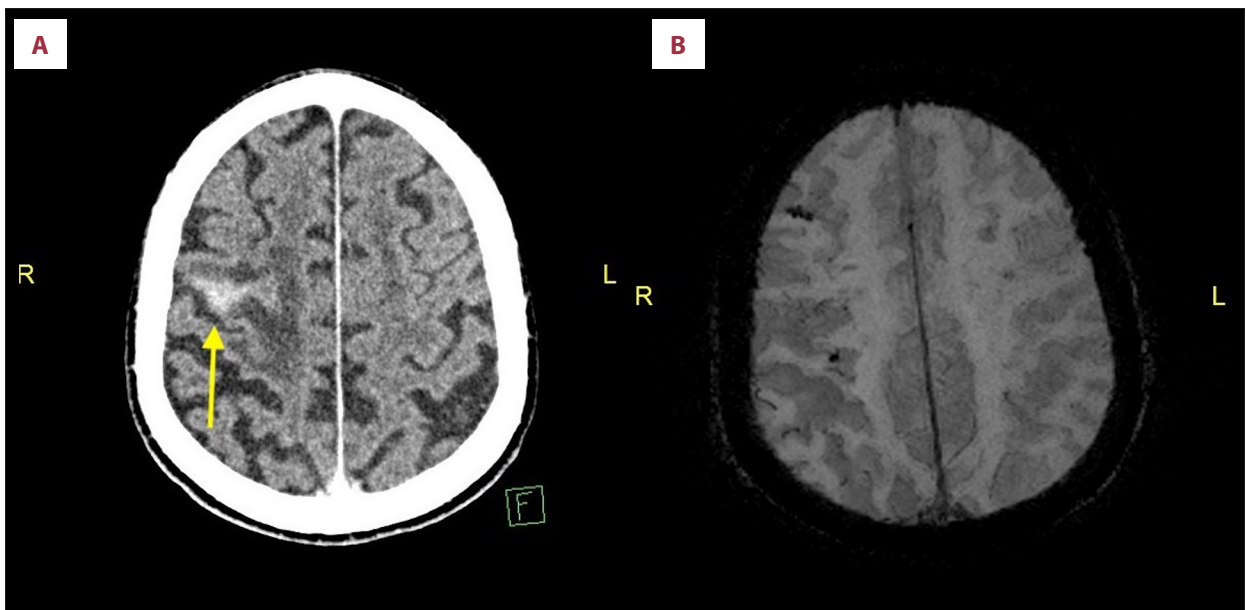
Axial view of CT head (A) showing hyperdensity (yellow arrow) and SWI-MRI (B) of the corresponding section not showing any signal drop-out in areas corresponding to the hyperdensity.
